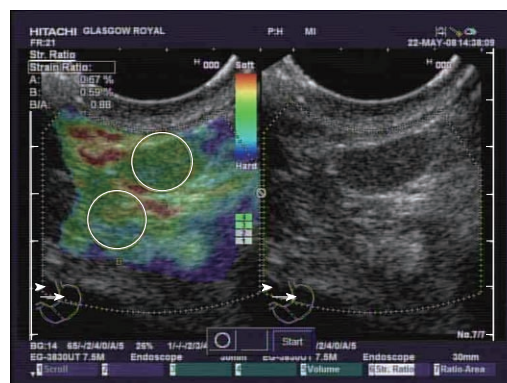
Endoscopic ultrasound elastography of a benign lymph node. The right-hand side of the image displays standard grey-scale endoscopic ultrasound images while on the left is a superimposed elastography image. In the elastography image window the strain ratio measurements of the two areas outlined in the yellow circles is shown as a percentage in the top left-hand corner. The calculated strain ratio is shown as B/A. The elastographic signal is indicated by the bar column in the bottom right of the elastographic image window.
